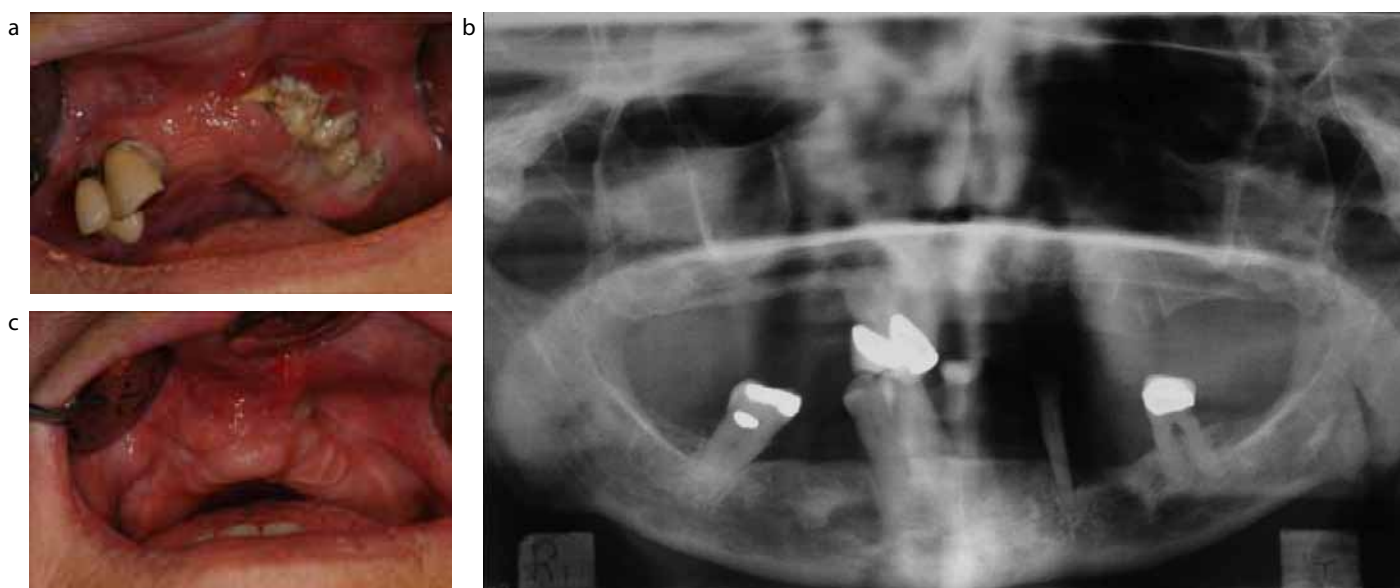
(a) Intra-oral view at presentation; patient prescribed intravenous bisphosphonate medication for previous 3 years with generalized discomfort from her mobile, periodontally involved maxillary teeth. (b) Panoramic radiograph at presentation. (c) Approximately twelve months following presentation and subsequent exfoliation of the remaining maxillary teeth, mucosal healing was almost complete.
